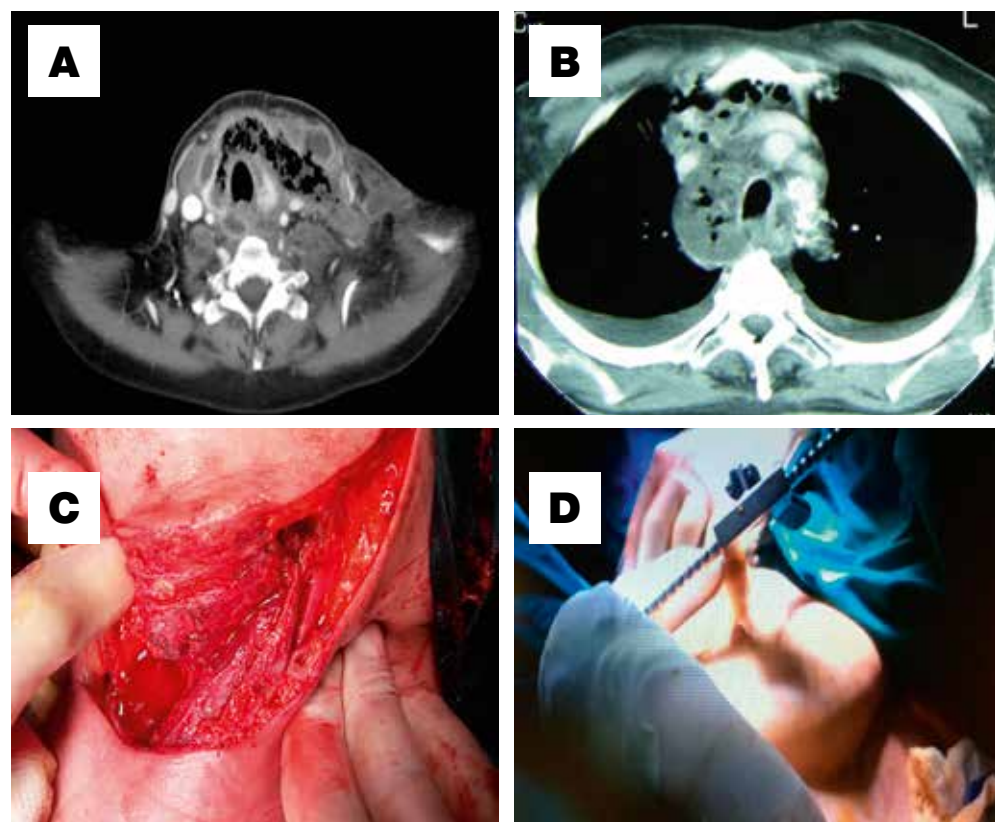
Cervical- and chest CT scan revealing gas bubbles and pleural infusion (A&B), and intraoperative drainage, irrigation and debridement (C&D)
